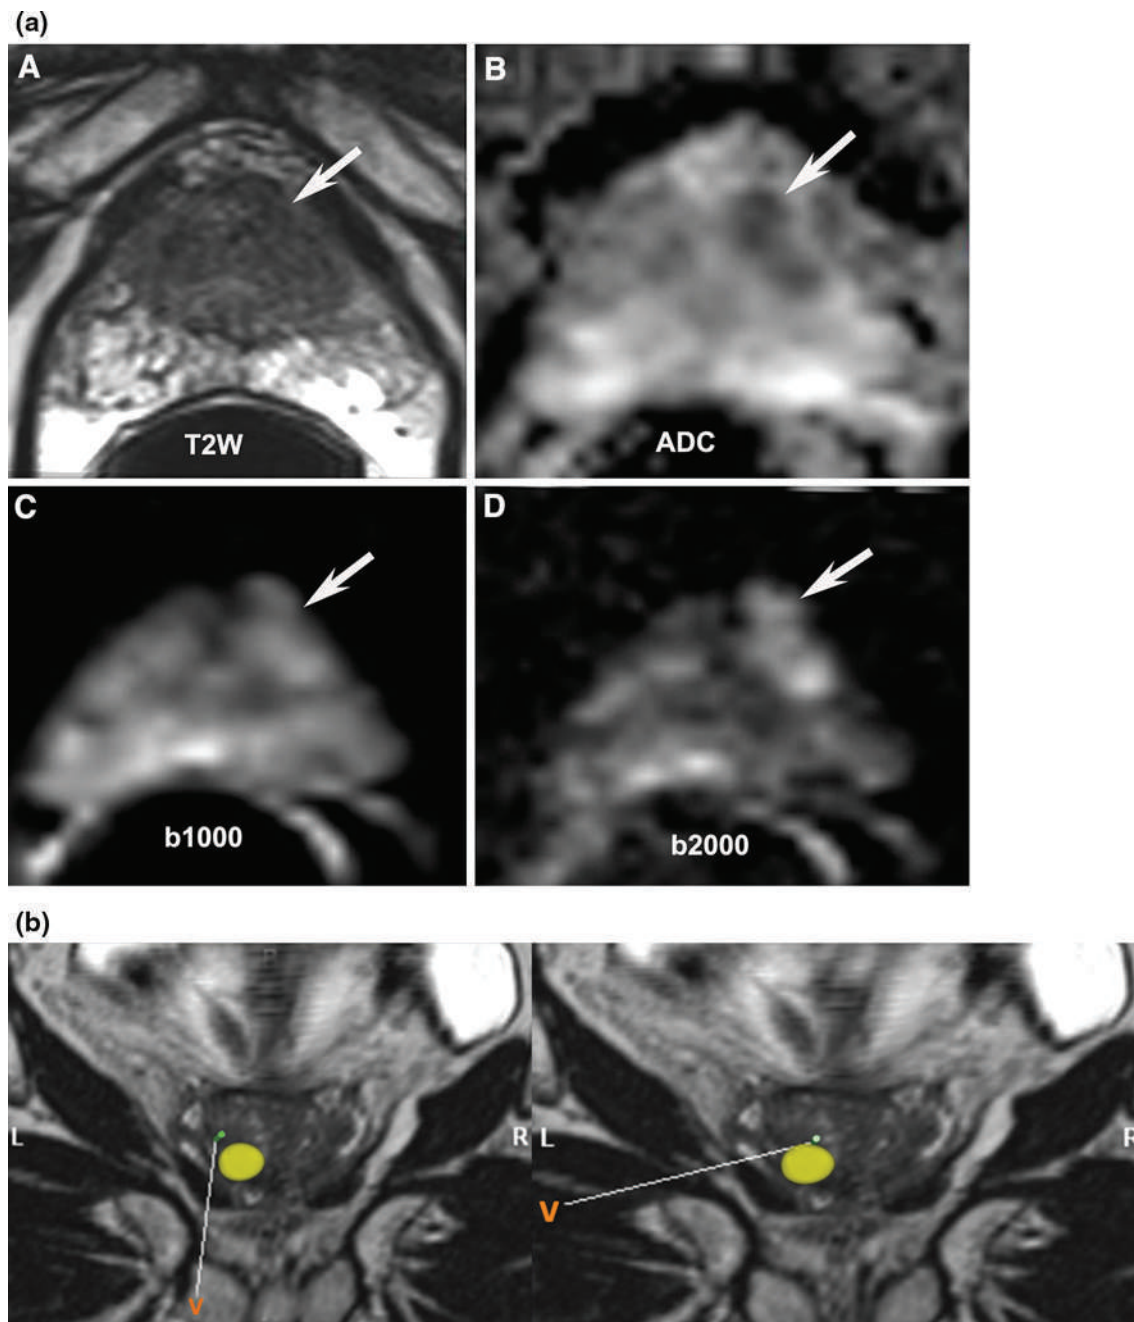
Elastic registration with virtual biopsies. a Low signal intensity area, barely visible on T2W-MRI (arrow, A), with a low ADC value (arrow, B) and high intensity signal on DW source images, visible on b-1000 image (arrow, C), but much more conspicuous on b2000 image (arrow, D). b Two virtual biopsies (V) showing that the needle tract does not traverse
